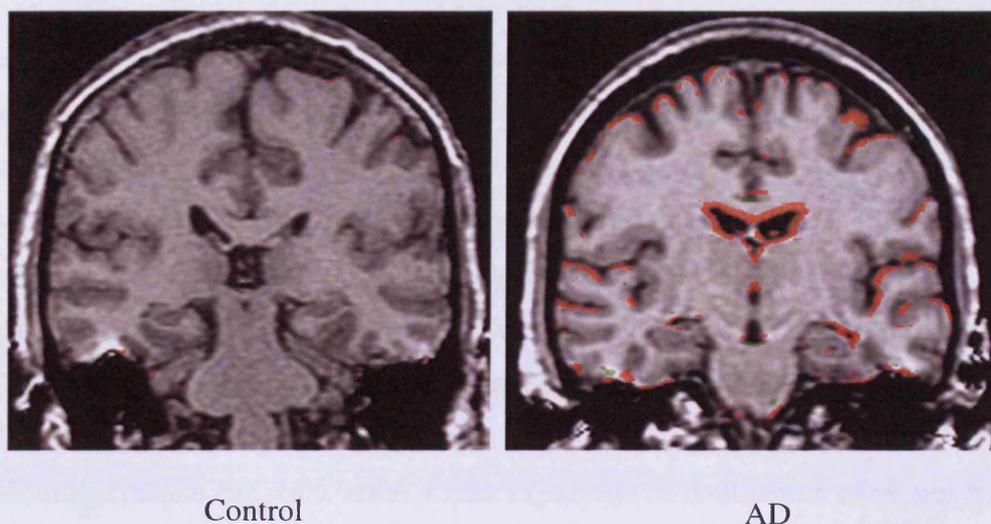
Measuring cerebral atrophy in registered serial MR imaging using the BBSI
